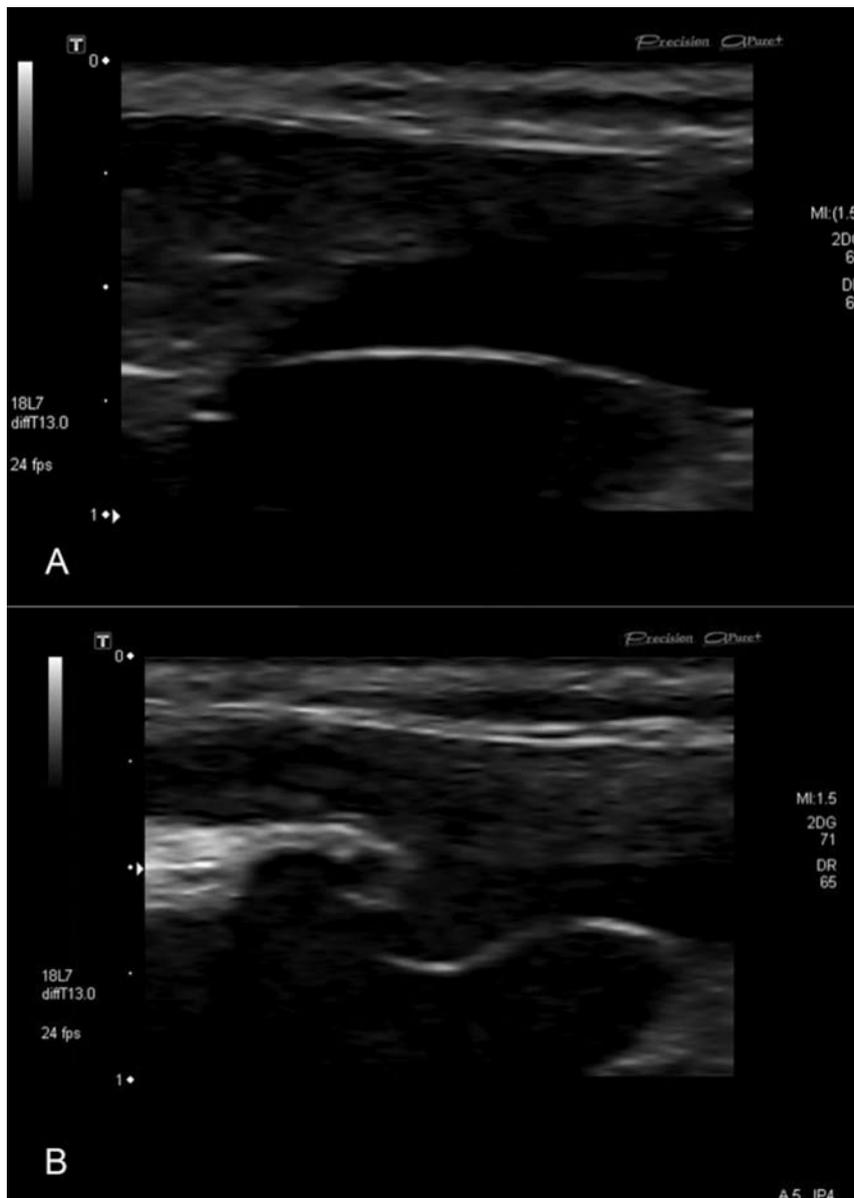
Images of competent monocuspid terminal valve. (A) The single terminal valve leaflet protruding across the lumen and on valsalva appearing to close against the opposite side of the vein wall. (B) Repeat B-mode ultrasound image, still without significant reflux to valsalva or distal augmentation, which revealed a previously unseen short irregular valve leaflet on the superficial wall of the great saphenous vein.
